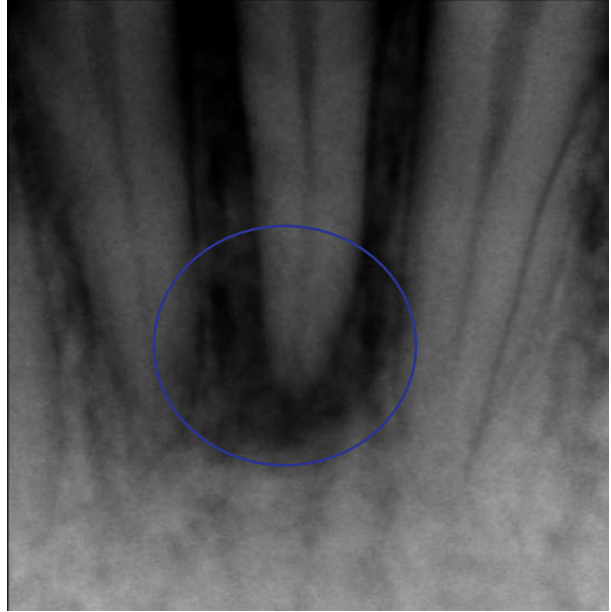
Initial radiographic image showing a periapical area of infection associated with tooth 31. The radiograph demonstrates a radiolucent area consistent with periapical inflammation and infection.
